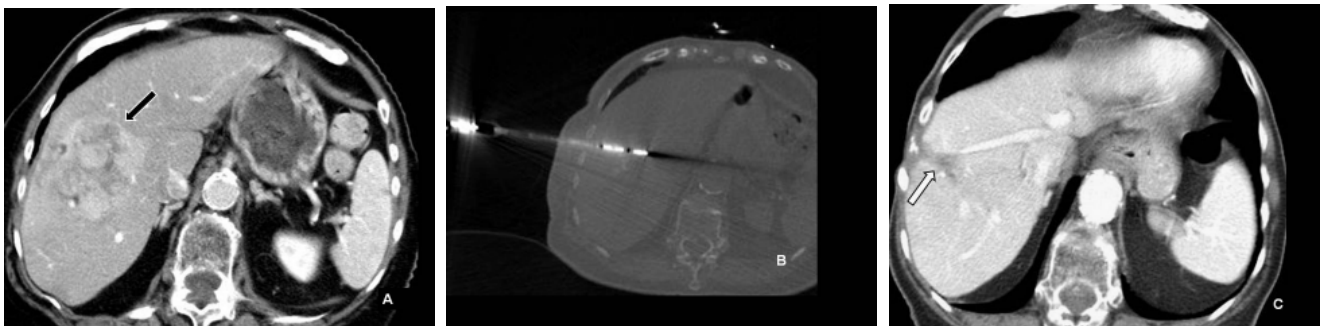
An 86 year-old female is shown on CT (left) to have a 6.6x6.0cm hypervascular lesion with an epicenter in hepatic segment VIII, extending to segment V (black arrow) consistent with hepatocellular carcinoma status post chemoembolization. Prior to ablation the patient underwent a second chemoembolization procedure to further reduce the size of this lesion. One month later the patient presented for MWA (center) and on 4-month post-ablation follow-up portal venous phase CT (right) the treatment zone shows post-ablation changes within segment VIII with no evidence of enhancement to suggest residual or recurrent disease within the ablation cavity (white arrow) now measuring 2.0x1.2cm.
